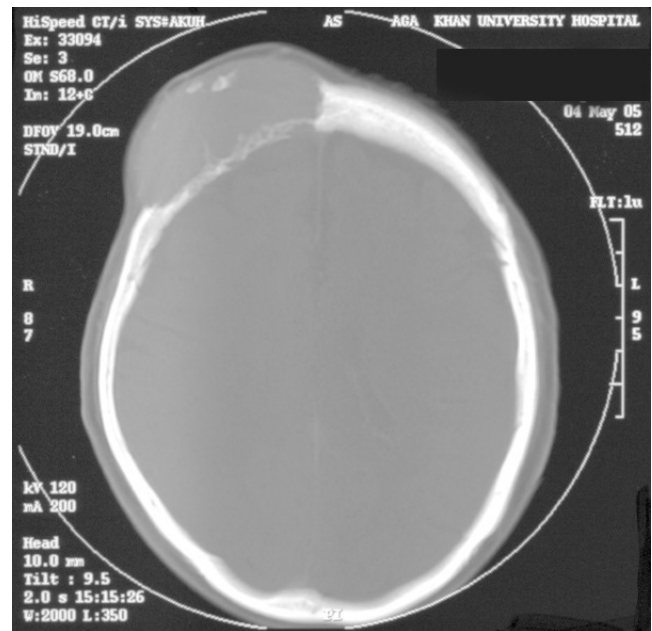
Preoperative CT scan, bone window showing an osteolytic lesion in the right frontoparietal region with overlying enhancing soft tissue component.
